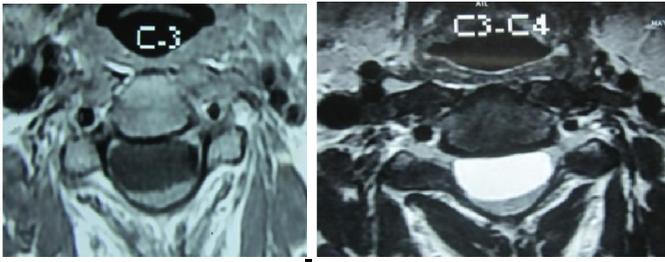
MRI T1 and T2W axial images revealing the cyst ventral to the cord and severely compressing and displacing the cord posterior
